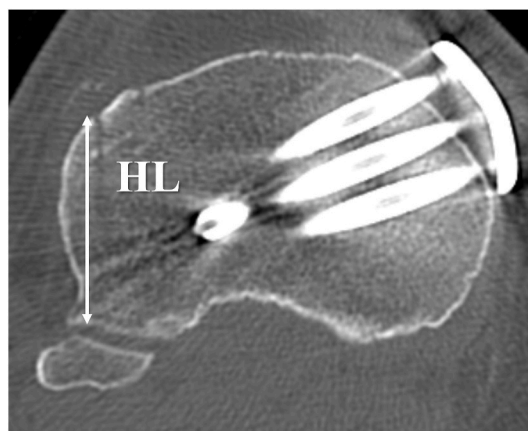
Measurement of hinge length (HL) on axial CT slices. HL (white two-way allow) was measured in the most proximal axial slice, where the hinge was visible.
